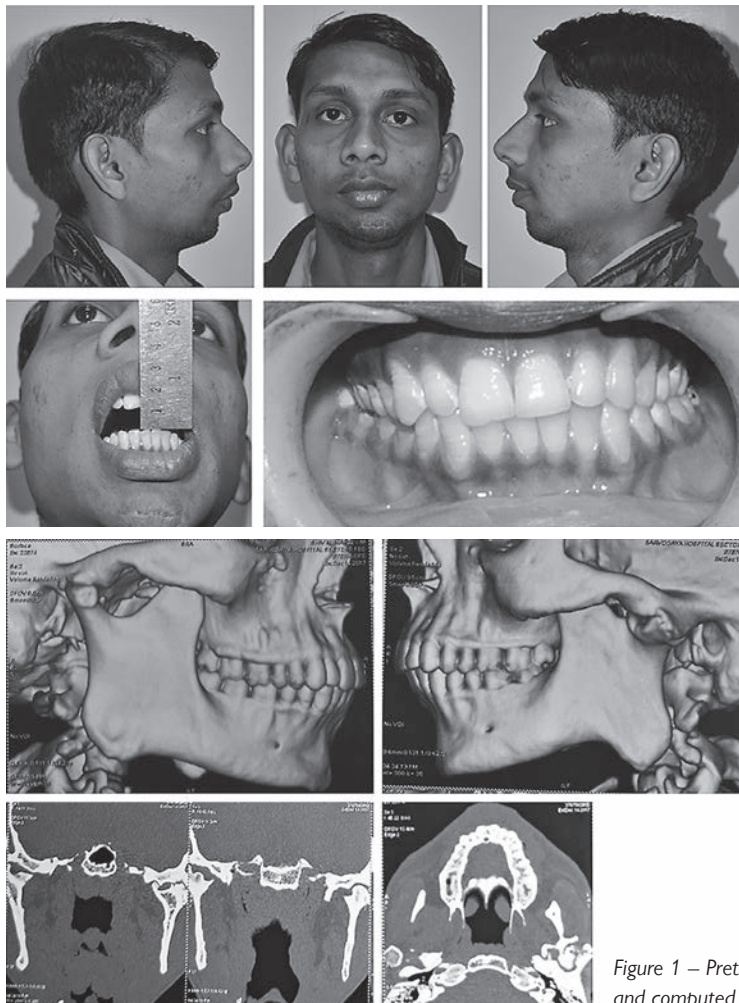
Pretreatment photographs and computed tomography images.
